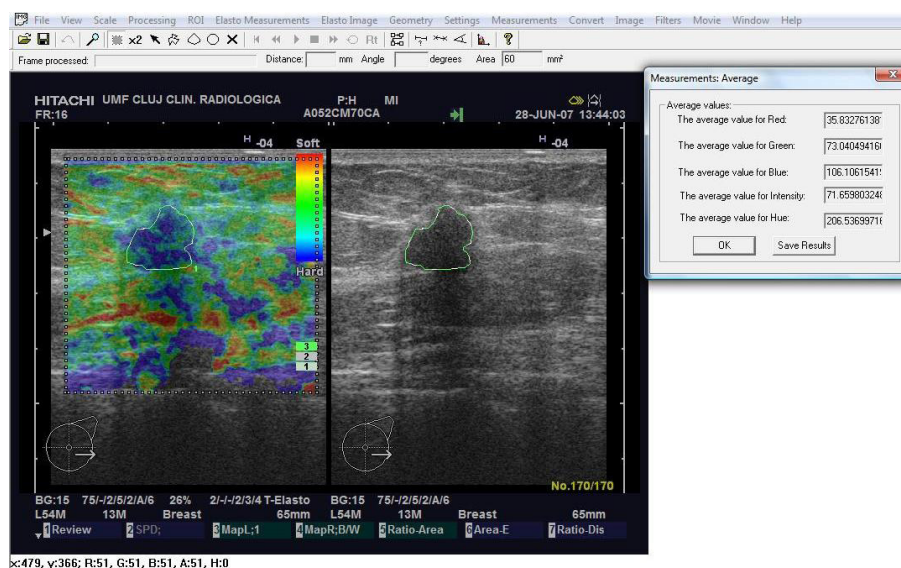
Non-palpable breast focal lesion displaying non-specific features on conventional ultrasound rising suspicion either for a mastopathic nodule (benign) or a carcinoma. The elastography heterogeneous appearance (blue-green) is doubtful between scores 2 and 4. The high numeric value for Avg Blue (106 -more than 92) and the smaller value for Avg Green (73 - less than 88) pleaded for a score 4, suspicious lesion. Pathology report: invasive ductal carcinoma.
